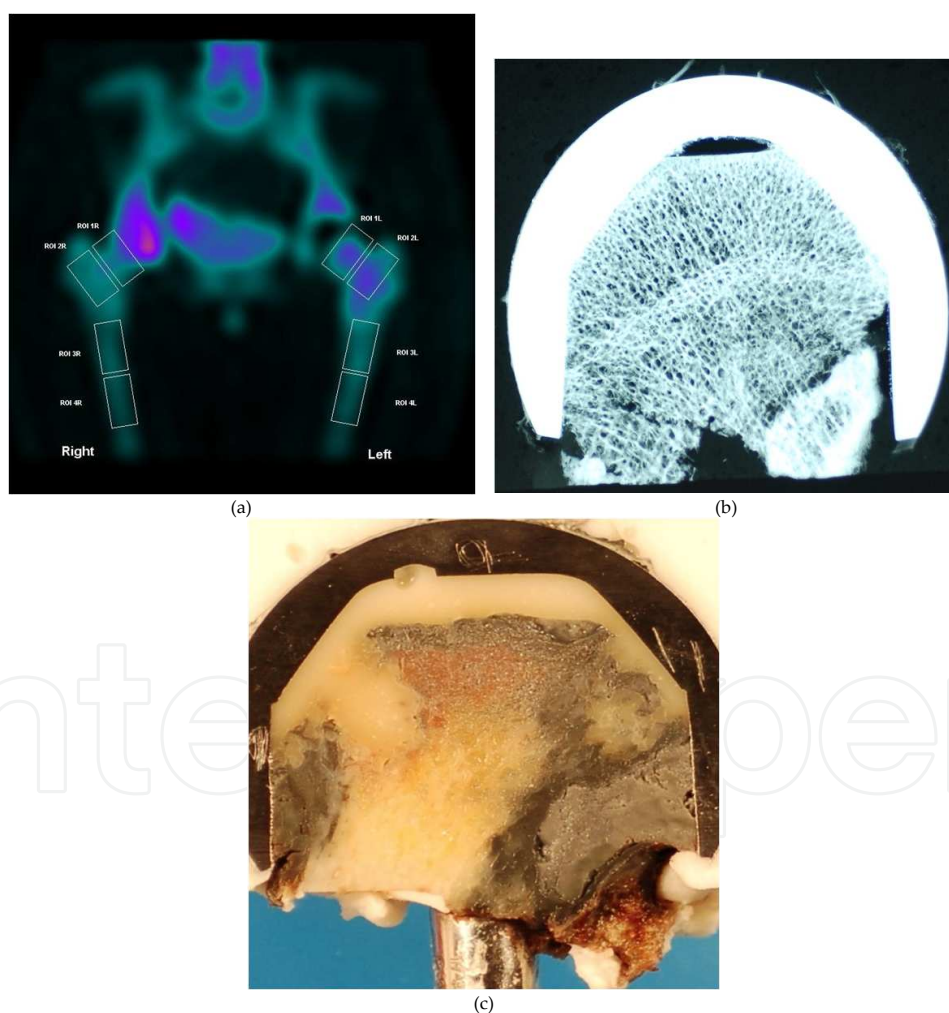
(a). Single cut section of a Single Positron emission Computed Tomography (SPECT) image. The most likely areas to develop AVN and fractures are ROI L (L: Operated, R: Normal). (b). Mocroradiograph shows bone thinning under the metal implant with a fracture at the lower margin. (c). The cut section of a retrieval head with metallosis and early pseudo-tumour formation
